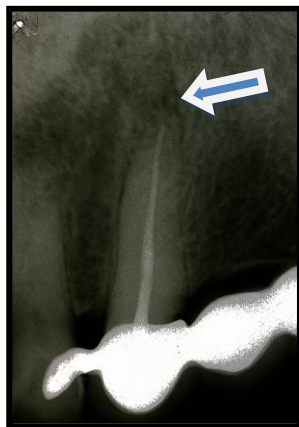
Diminution of periapical radiolucency
